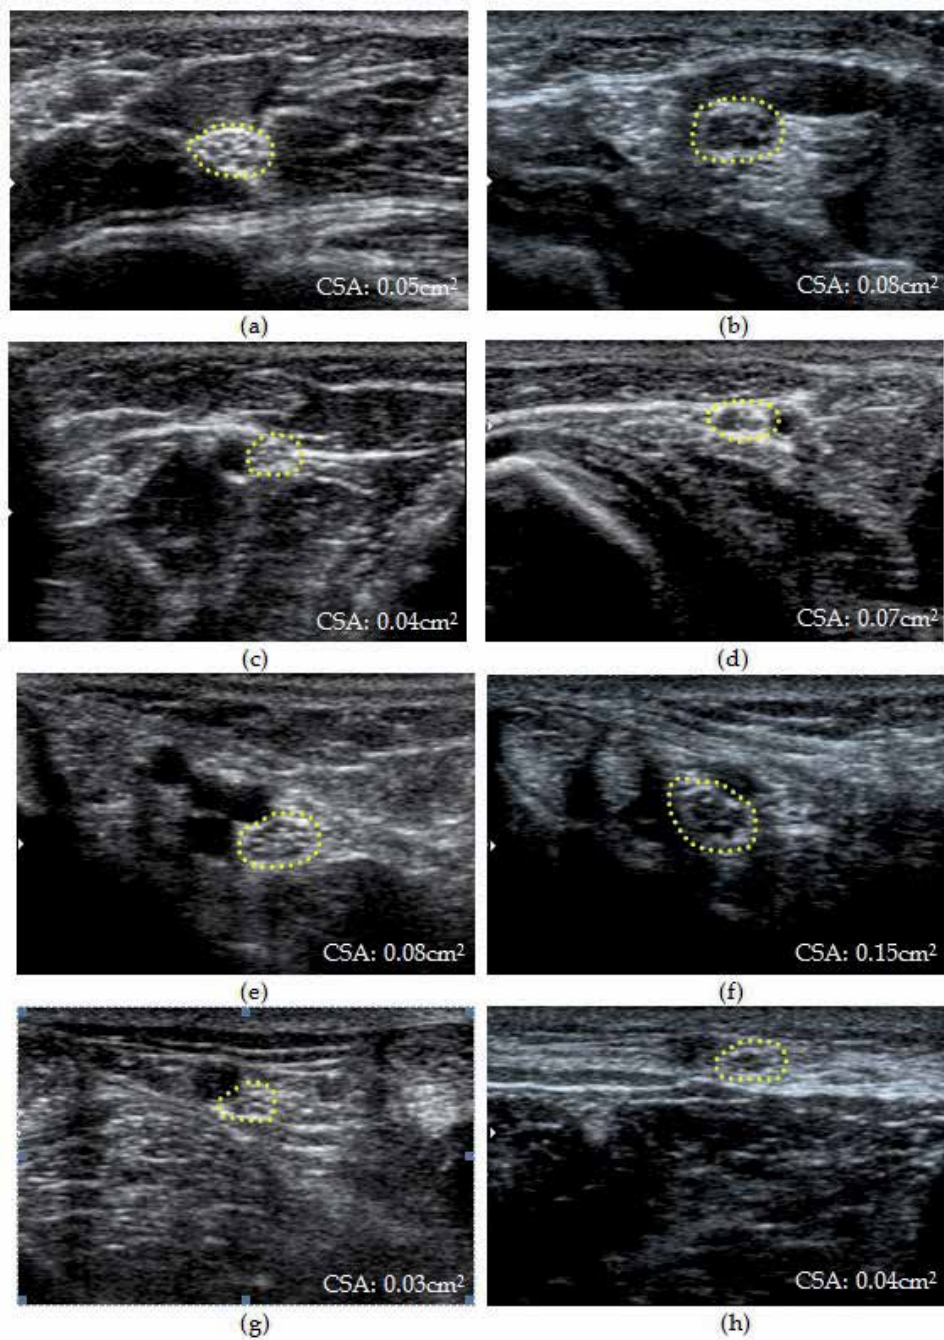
Comparison of the nerves in controls and in diabetic patients. Transverse image of the median nerve in control' wrist (a), and in diabetic patient's wrist (b). Transverse image of the ulnar nerve in control' wrist (c), and in diabetic patient's wrist (d). Transverse image of the tibial nerve in control' ankle (e), and in diabetic patient's ankle (f). Transverse sonogram of the sural nerve in control' ankle (g), and in diabetic patient's ankle (h).
